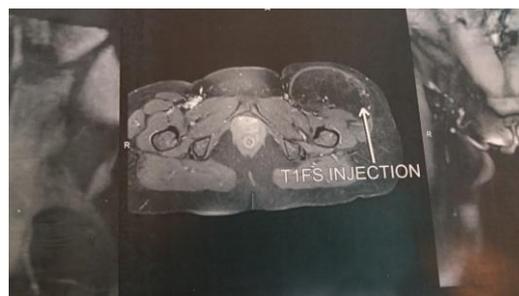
T1 with fat suppression MRI scan
